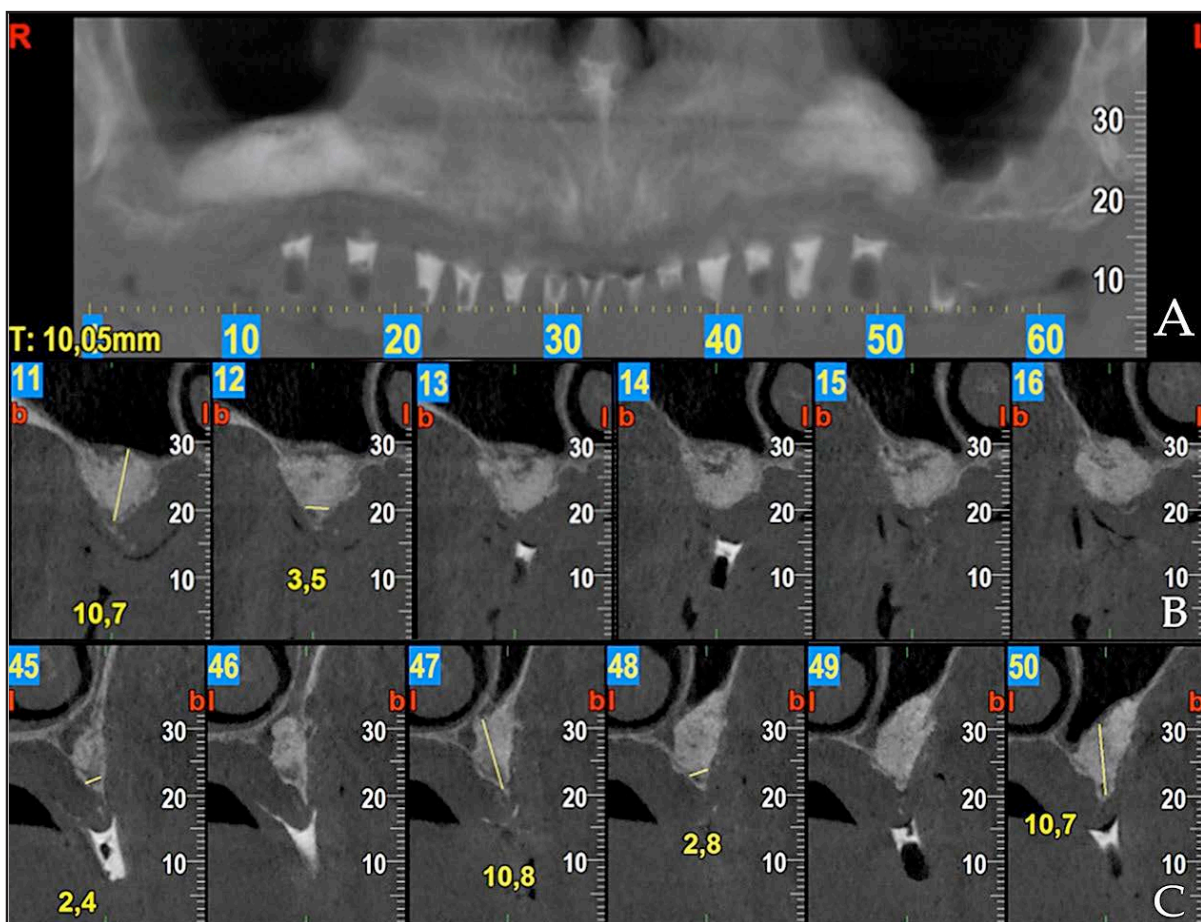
Post-operative CBCT (6 months after the sinus elevation surgery). A, B, C: There was an increase of 10.7 mm and 10.8 mm in the height of the alveolar crest, and an increase in the alveolar crest width of 3.5 mm and 2.8 mm in the right and left side, respectively.
